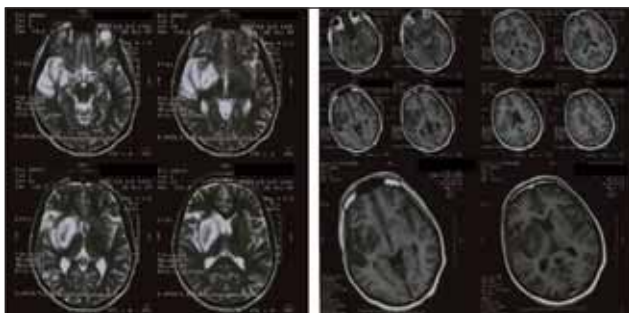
Cerebral MRI examination. Right MCA territory infarction.
